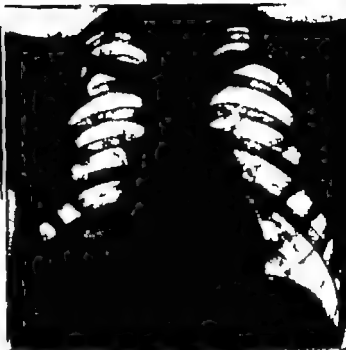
15 —Male infant aged 6 months, admitted as an emergency with acute dyspnoea and stridor following on a month's illness, having been in contact with his father suffering from open tuberculosis The radiograph in addition to characteristic "epituberculosis" of the right upper lobe, shows gross obstructive emphysema of the right lower lobe and of the left lung Emergency right thoracotomy showed caseating glands compressing the trachea into which perforation had occurred at the point of origin of the right main bronchus Excision of glands, suture of the perforation and temporary tracheotomy led to immediate relief Subsequently a good recovery with the aid of chemotherapy (Mr S J MacHale)
